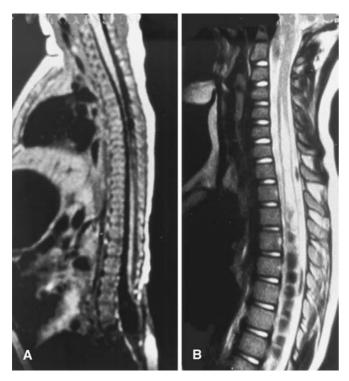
MR images of an infant with a myelomeningocele, Chiari II malformation, and hydrocephalus. A, note the normal cord during shunt function and B, that a shunt malfunction produced hydromyelia
